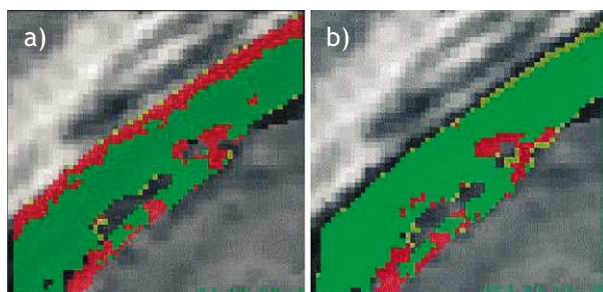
a) shows a small 3-D sub-volume extracted from a larger registered CT-MR image pair. In the middle the color-coded overlay visualizes the registration assessment result for bone structures. In (b) the CT and MR sub-volumes have been re-registered to each other using a mutual information algorithm. The re-registered sub-volumes exhibit a strongly improved registration assessment result, the low-accuracy (red) region is greatly diminished.
